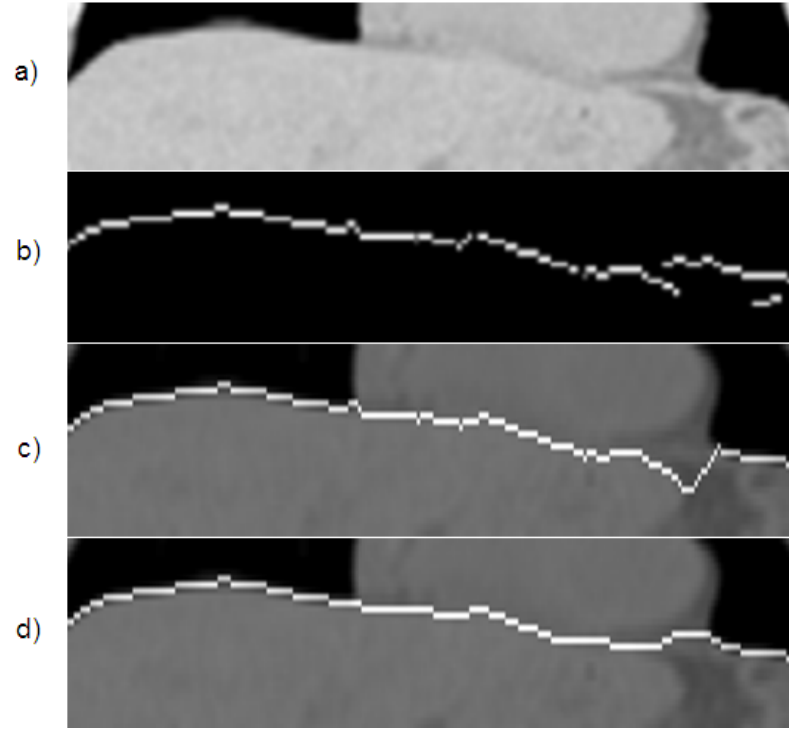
a) A coronal CT slice over extent of the diaphragm, b) the binary map of edge-pixels for this slice, c) the initial estimate of the diaphragm outline overlaid on the CT image, containing an error where the liver boundary deviates from the diaphragm and d) the final estimate following the piece-wise solution search, in which the error is rectified.
